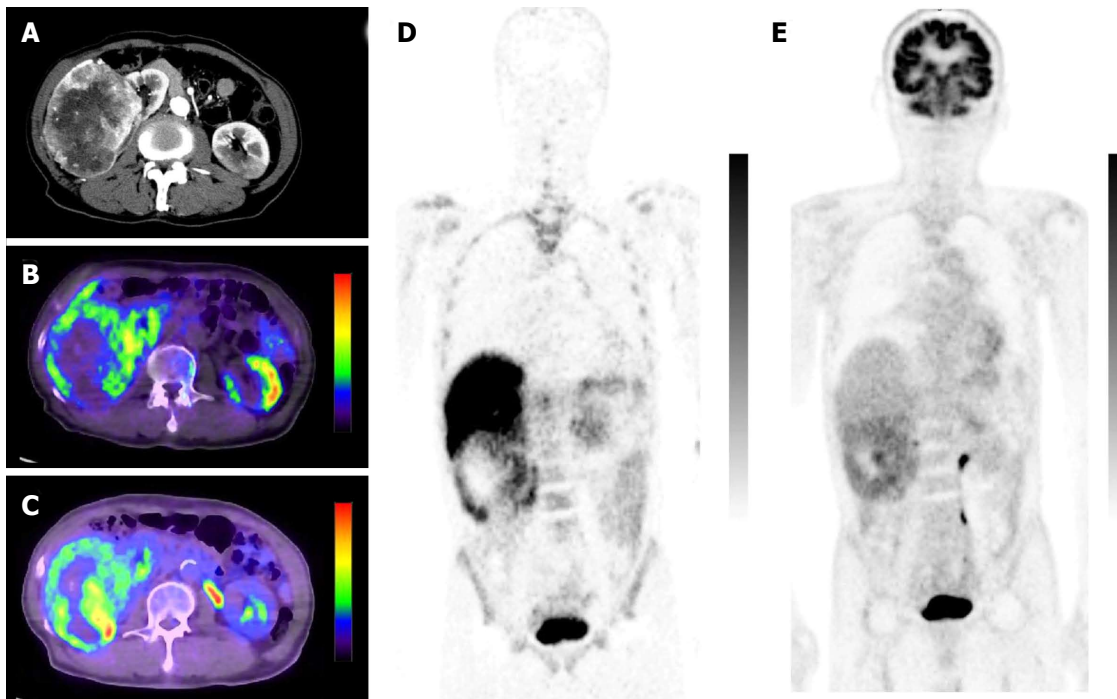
4'-[methyl- ^{11}C]-thiothymidine images in clear cell renal carcinoma. A 78-year-old male with a clear cell renal carcinoma (RCC) in the right kidney. Contrast-enhanced abdominal CT (A), fused ^{11}C -4DST PET/CT (axial image) (B), fused ^{18}F -FDG PET/CT (axial image) (C), coronal ^{11}C -4DST PET (D), and coronal ^{18}F -FDG PET (E) images are shown. The uptake of ^{11}C -4DST was predominantly near the outer surface of the RCC tumor; the uptake of ^{18}F -FDG was more diffuse. Reprinted from Minamimoto *et al*^[25], with the permission of Springer. ^{11}C -4DST: 4'-[methyl- ^{11}C]-thiothymidine; ^{18}F -FDG: 2-Deoxy-2-[^{18}F]fluoro-D-glucose; PET: Positron emission tomography; CT: Computed tomography.
